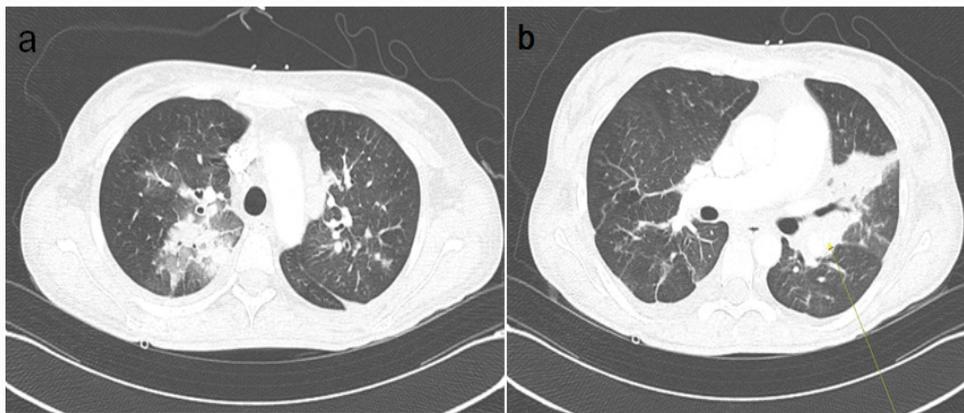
Lung CT scan showing multifocal thromboembolism in segmental pulmonary artery of right upper lobe (a) and left upper lobe (b). Arrow indicate poorly defined nodule like thromboembolism.
